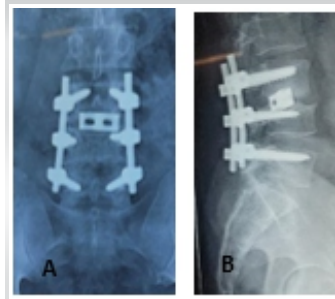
6 month's post-operative X-ray showing fusion at L3-4 level. A: A/P, B: Lateral view
